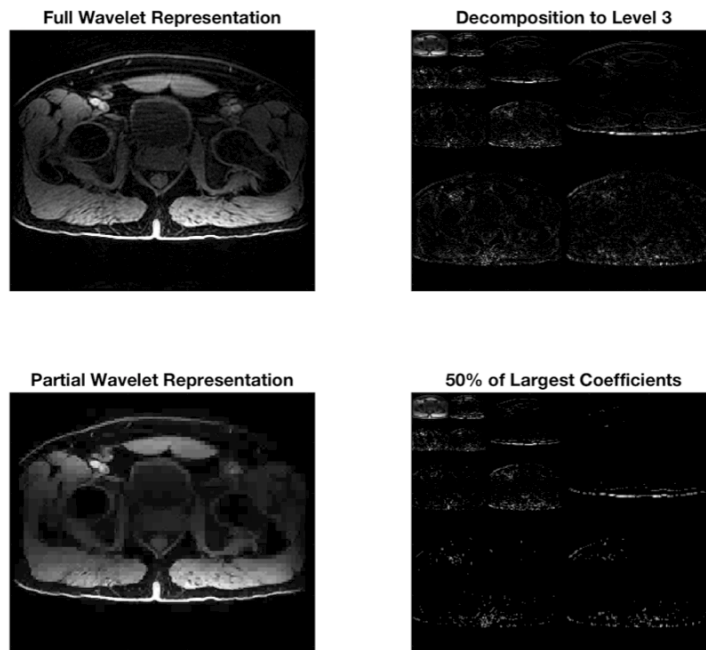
Medical images are often compressible in the wavelet domain. By retaining 50% of the wavelet coefficients in a pelvic MRI image, a decent reconstruction is still possible.
